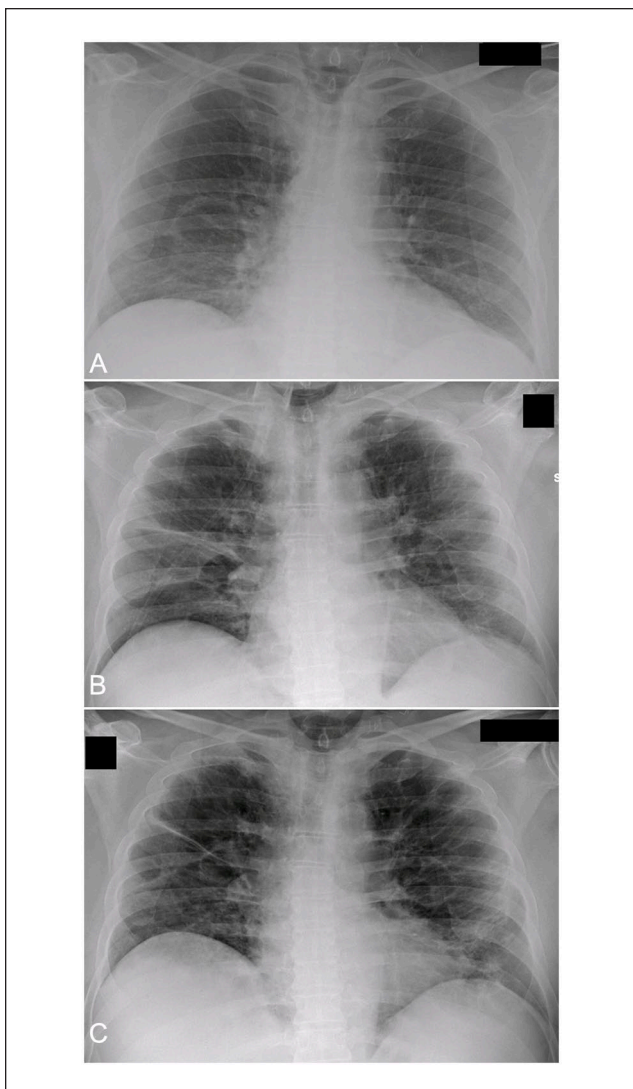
(A) Chest radiograph performed on March 11, 2020 (day of admission): interstitial-alveolar infiltrates involving the right basal segment and the left parahilar area. (B) Chest radiograph performed on March 18, 2020 (day 7): bilateral involvement of the middle lung fields. (C) Chest radiograph performed on March 30, 2020 (day 19): improvement with reduction of medio-basal infiltrates on the right lung.
